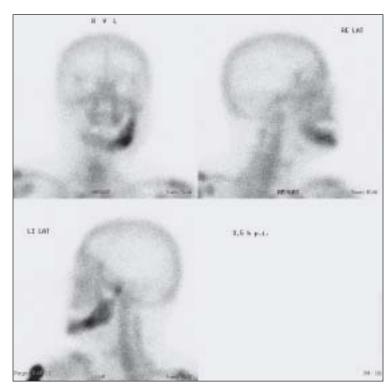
99Tc<sup>m</sup>-MIBI scintigraphy showing strong uptake in the left mandibular corpus and ramus.
